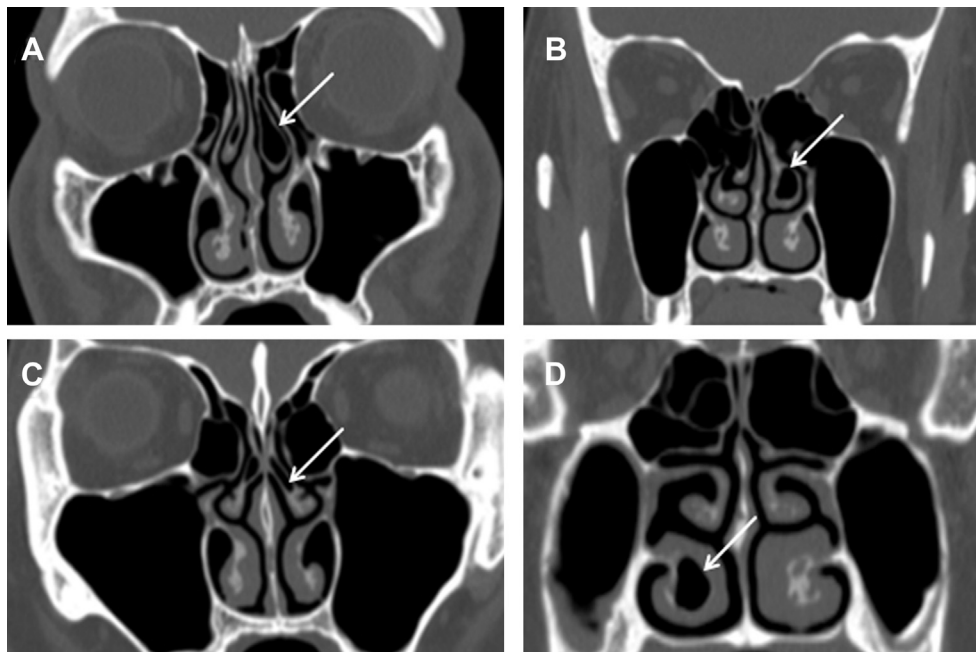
Coronal scans of preoperative dental CT. (A) True type (arrow). (B) Bulbous type (arrow). (C) Lamella type (arrow). (D) Right inferior concha bullosa (arrow).
